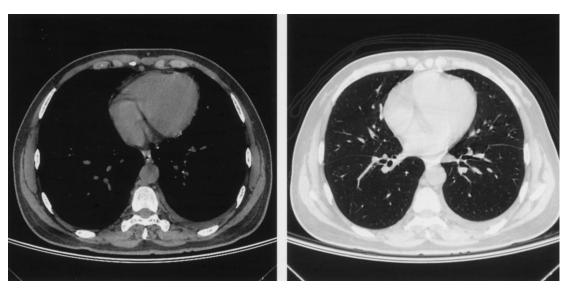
Chest CT showing only left-side pleural effusion and trivial pleural change, but no mediastinal lymphadenopathy or lung parenchymal lesion.
